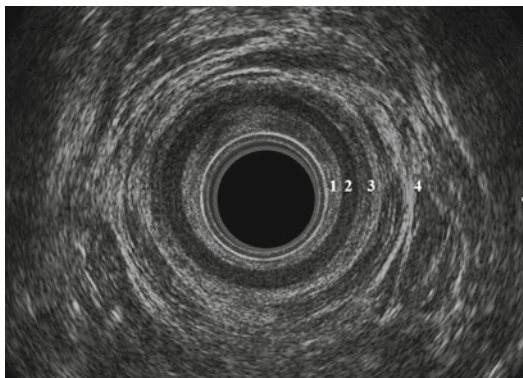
Endoanal ultrasound image showing the various layers seen: 1 Subepithelium, 2 IAS, 3 Longitudinal muscle layer, 4 EAS
